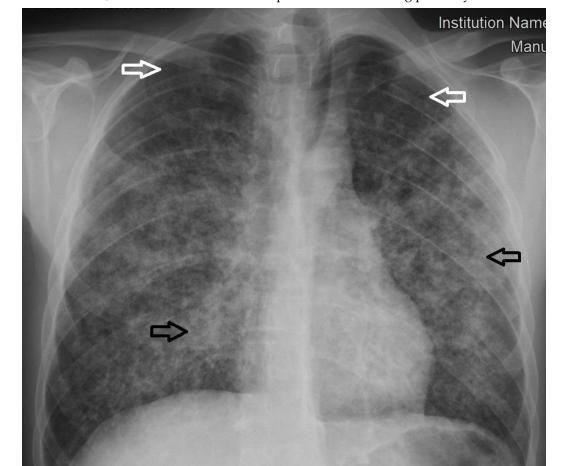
Initial chest X-ray. Black arrows indicate diffuse bilateral micronodular ill-defined infiltrate, and white arrows indicate spared areas of the lung parenchyma.
